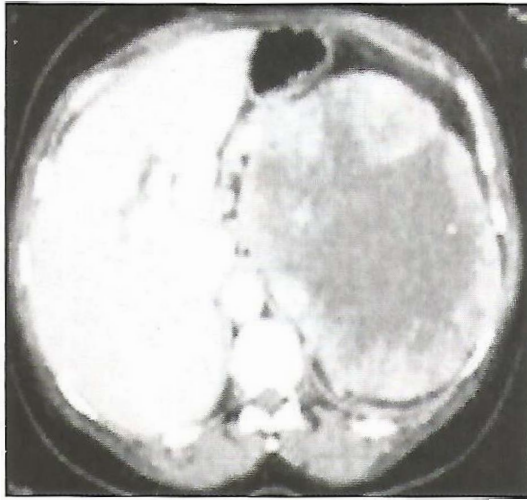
CT-scan - Retroperitoneal mass.
